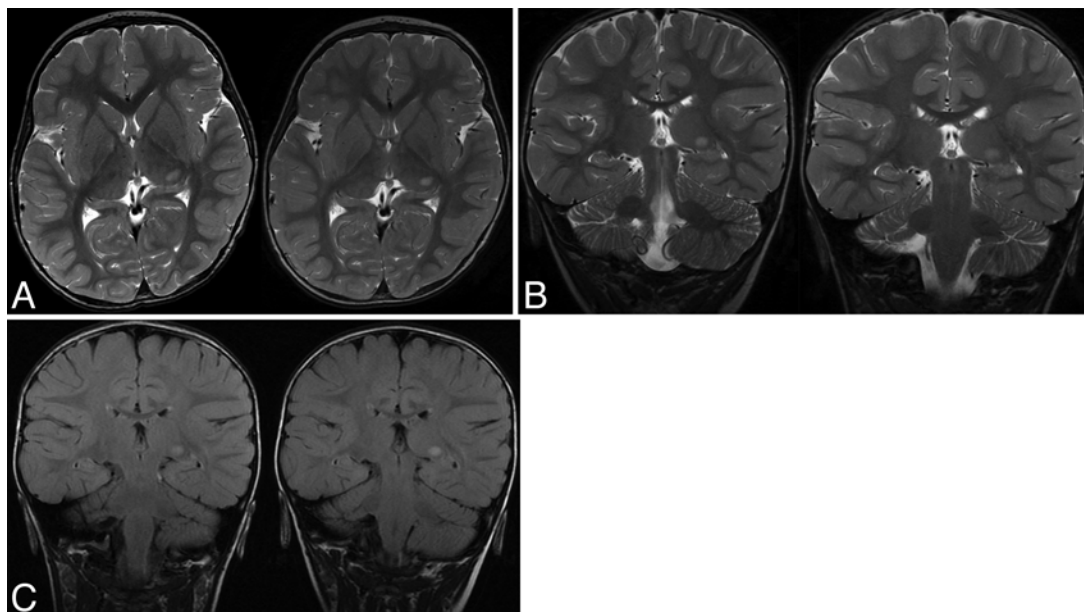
Case 14. Incidental thalamic mass lesion (assumed diagnosis of LGG) in a 2.1-year-old boy presenting with a nasal fistula. Axial (A) and coronal (B) T2-weighted MR and coronal FLAIR (C) images. *Left panels* were obtained initially. *Right panels* show the lesion after a period of 16 months of wait-and-see.
